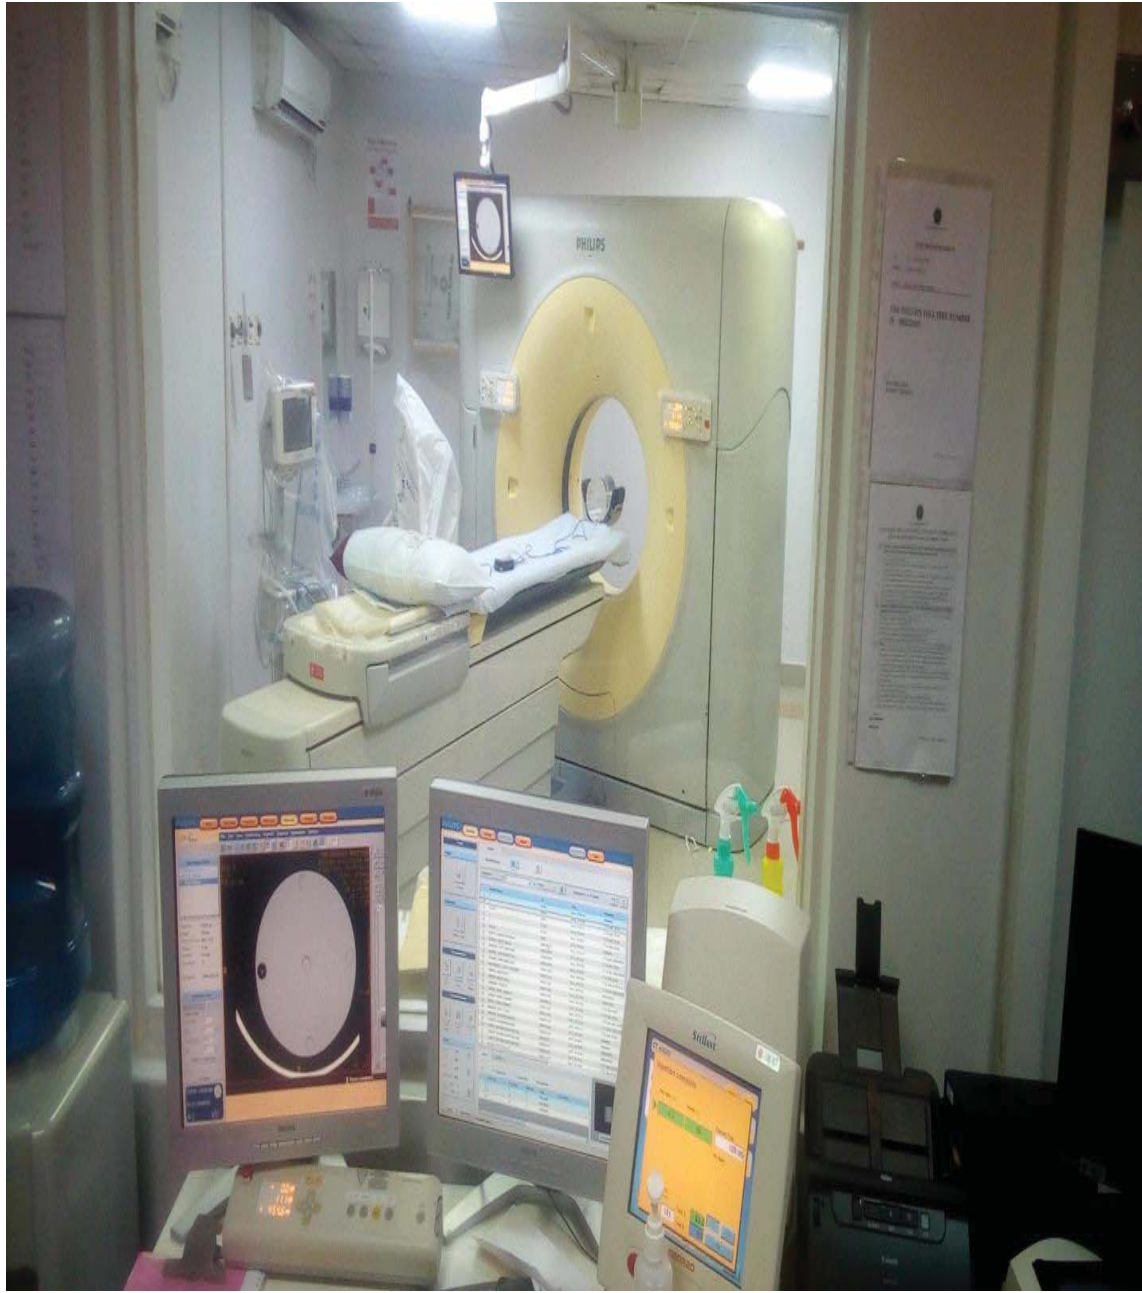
Console System and Philips Brilliance 64-slice CT scanner at the Nairobi Hospital
